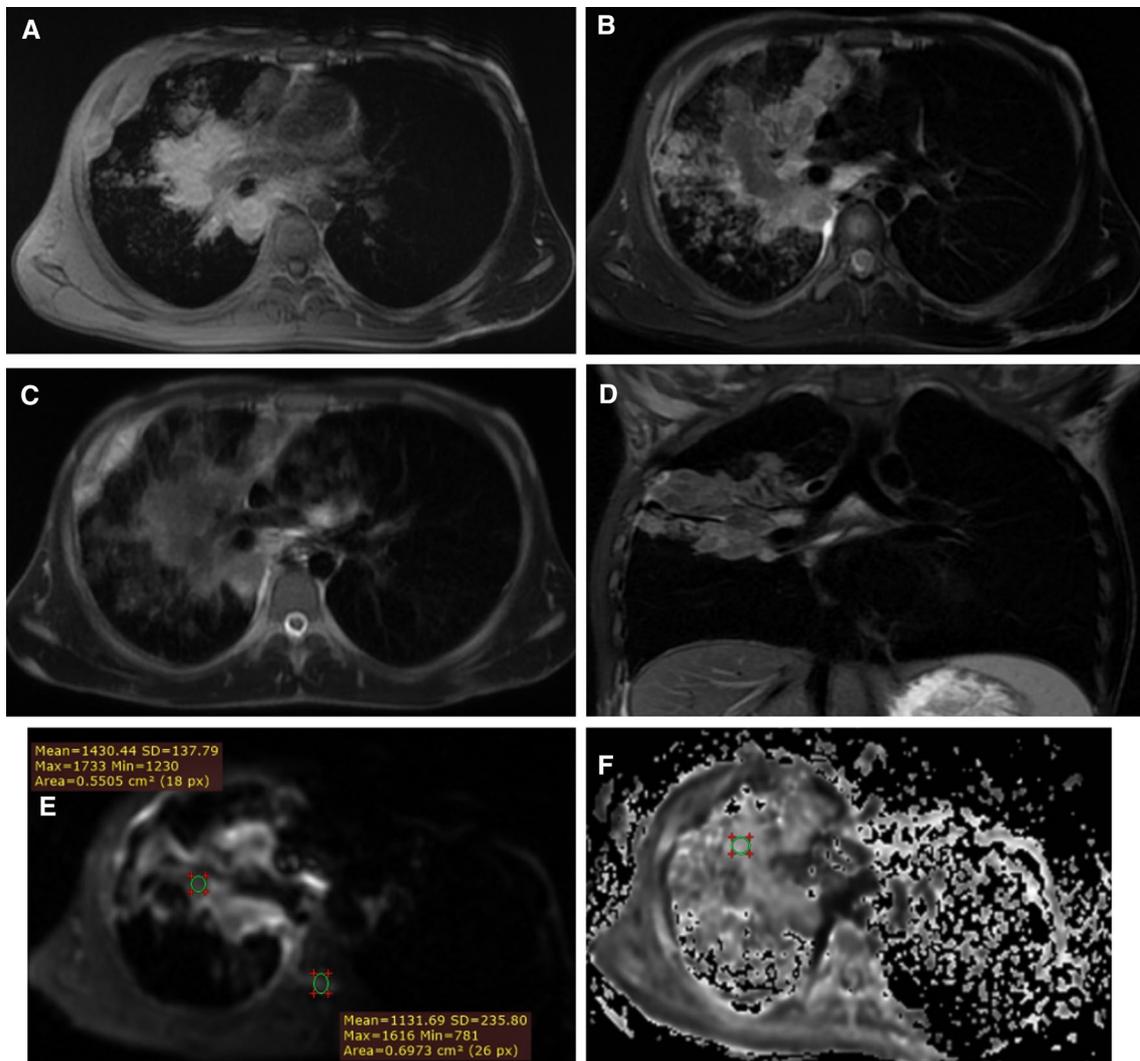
Female patient 72-years-old presenting with dyspnea and cough. A-D: Axial T1 (A), axial T2 (B), axial STIR (C), coronal STIR (D), weighted MR images show left upper lobar cavitory lesion with soft tissue within and surrounding consolidation. They elicit isointense T1 signal and hyperintense T2 signal relative to the surrounding muscles with air crescent sign. DWI (E) and ADC map (F) images show facilitated diffusion and LSR=0.58, ADC mean value 1.85 with ADC min value 1.51. Bronchoscopic examination with brocho-alveolar lavage and cytology revealed fungal infection (aspergilloma)
